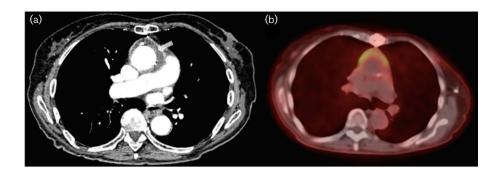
(a) CT scan of the aorta showing aortitis of the ascending aorta starting distal to the bioprosthesis. (b) PET scan showing increased periaortic activity.
